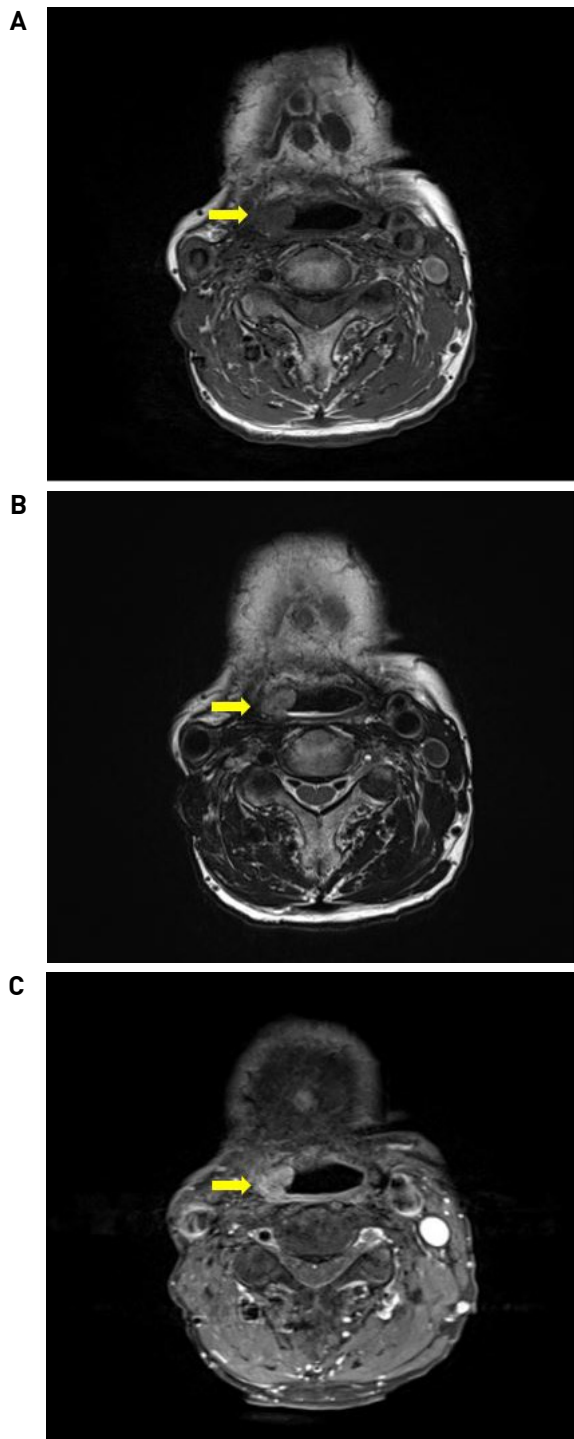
Mass is found along the lateral neopharyngeal wall in both T1 (A) and T2 (B) MRI image. In T1-CE MRI image, enhancing lesion is found from tongue base to pharyngoesophageal junction (C).
